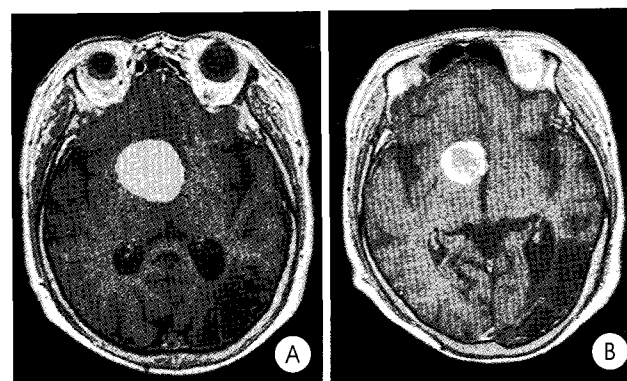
Case No 5. Initial gadolinium(Gd) enhanced axial T1 weighted magnetic resonance(MR) image (A) shows well-enhanced mass located in right frontal lobe. One month later radiosurgery, T1 weighted Gd enhanced axial MR image (B) reveals that reduction of original mass.
